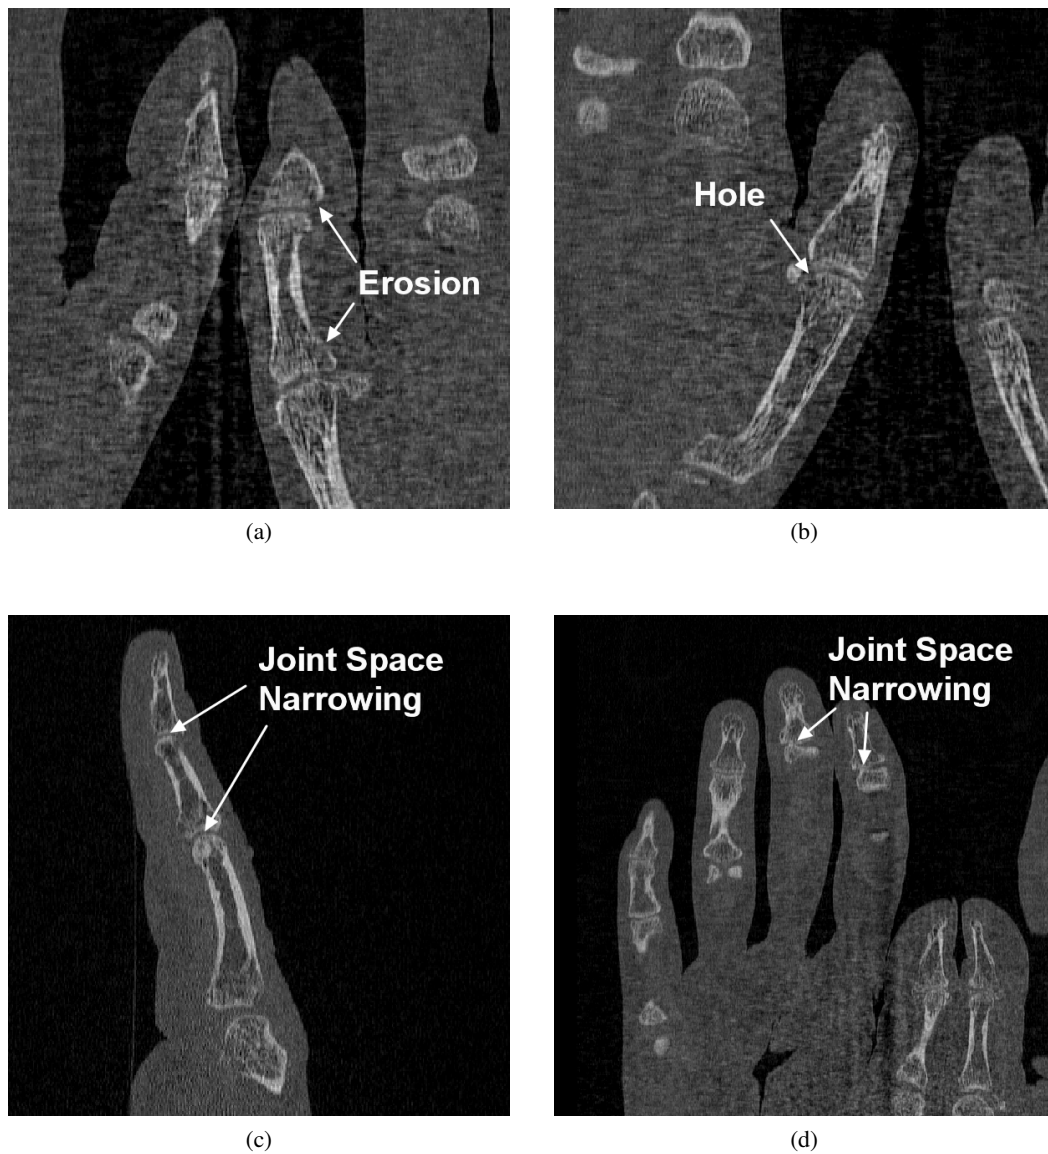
Effects of RA present in the CT data: In (a & b) erosions and holes in the bone structure can be seen. Joint space narrowing and its effects can be seen in (c & d).
